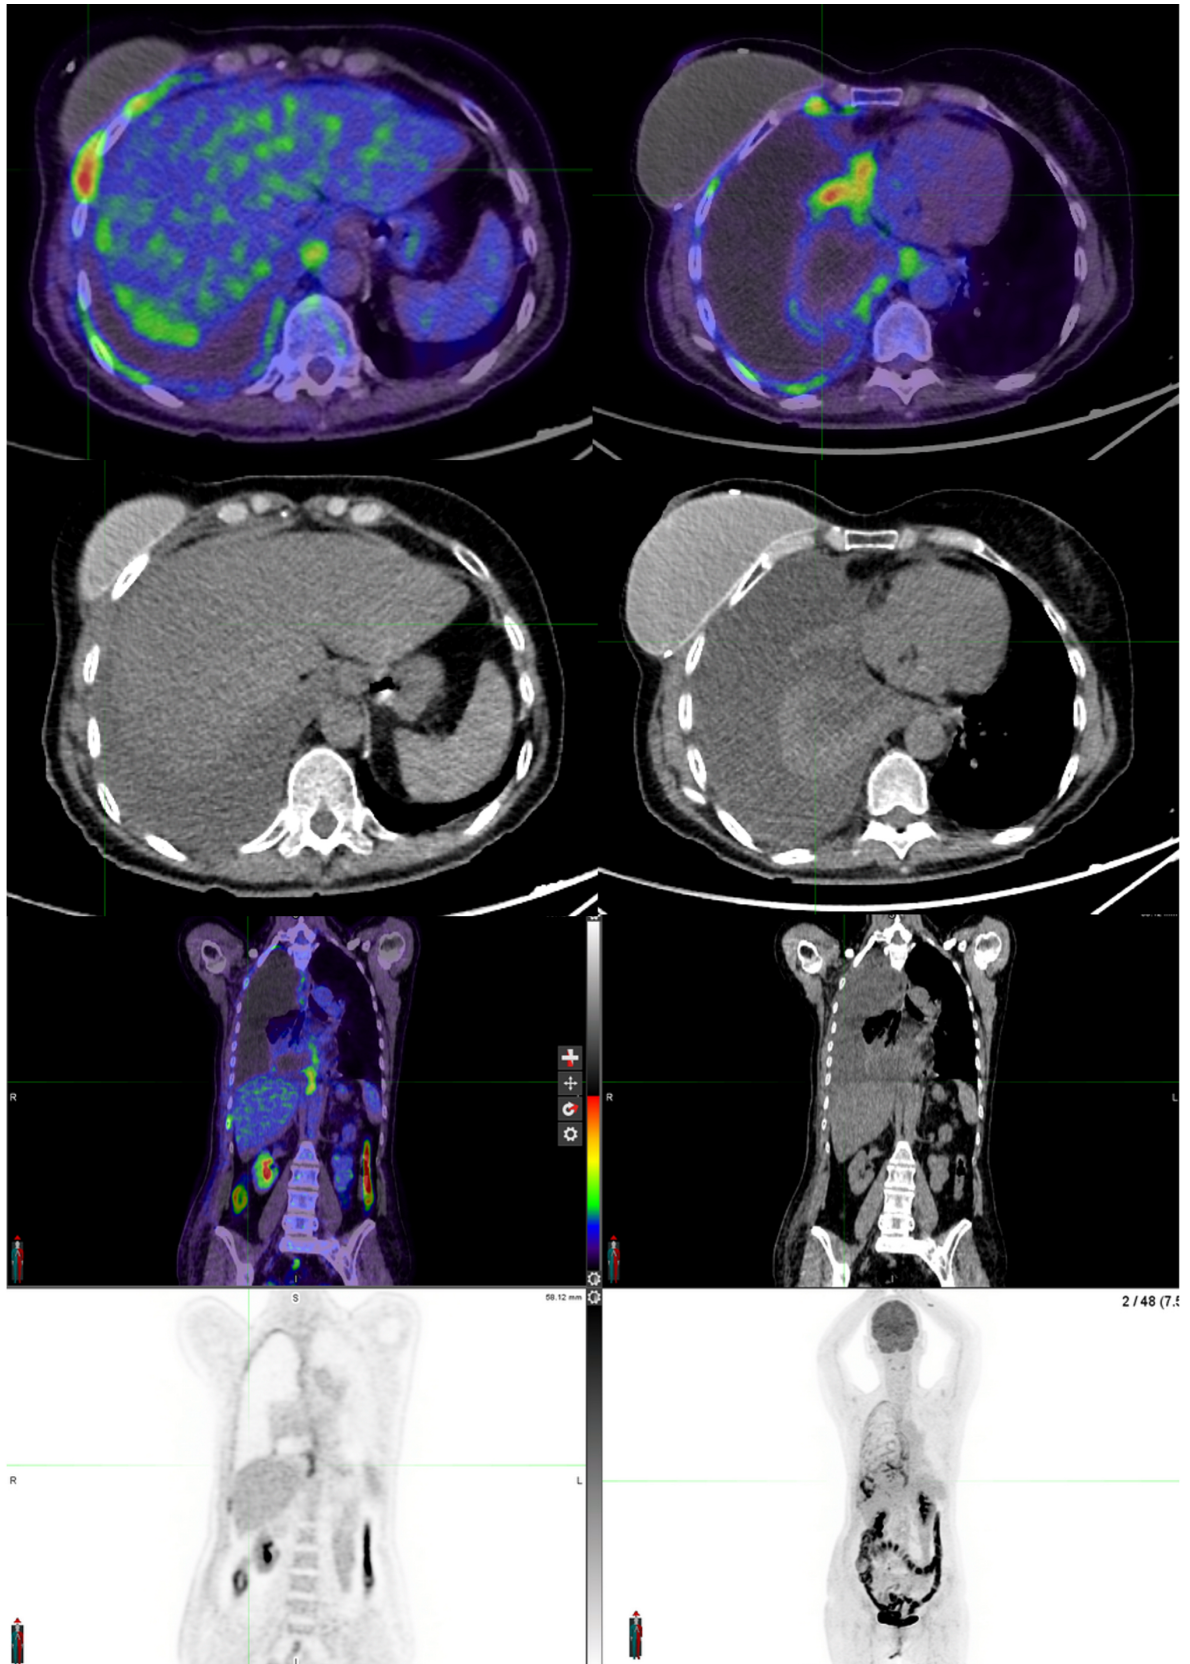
Positron emission tomography (PET)-computed tomography (CT) of the chest demonstrating [18FDG] flurodeoxyglucose-avid areas within inferolateral aspect of right breast implant and avid right pleural involvement and effusion.
